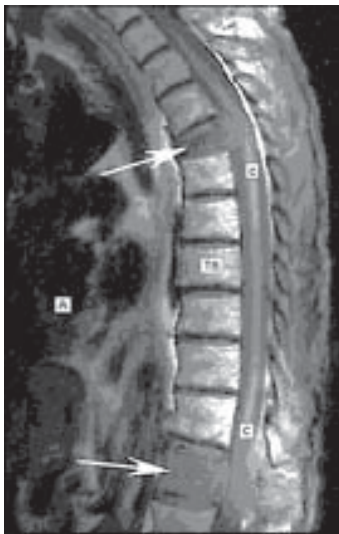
T1Weighted MRI showing vertebral body metastasis causing cord compression.
